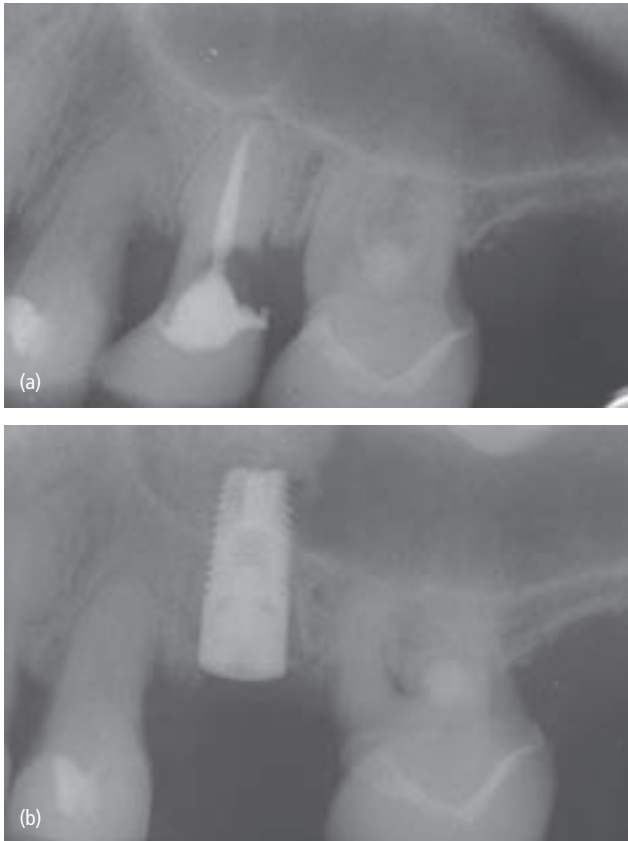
(a) Periapical radiograph suggesting a septum in the sinus at the area of the maxillary left second premolar. (b) Osteotome sinus elevation in the area of the second premolar. Sinus elevation was accomplished at the mesial aspect but not at the distal aspect, which was limited by the anatomic septum present. (c) Final crown in place showing stability to the grafted sinus and implant. (Prosthetic care was performed by David Faust, DMD, Yardley, Pennsylvania, USA.)
